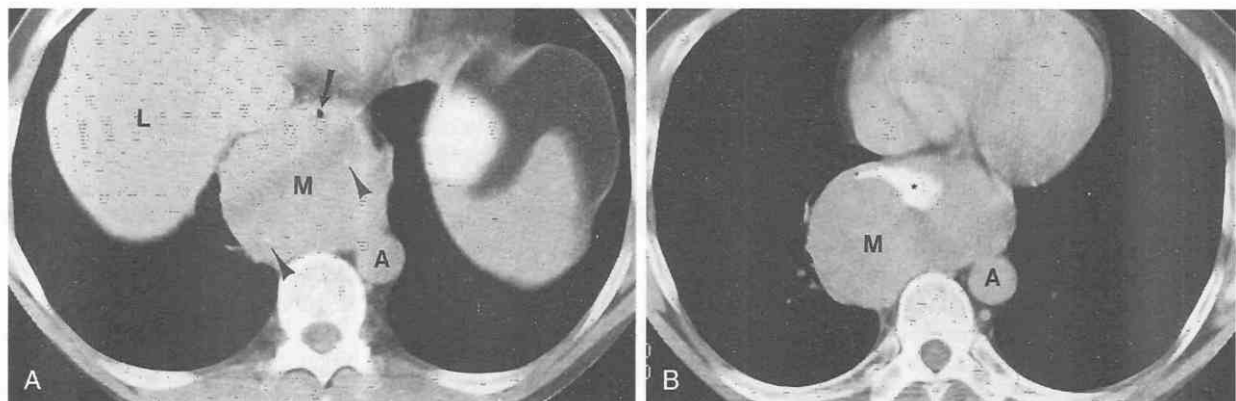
Esophageal leiomyoma. *A*, CT shows large middle-mediastinal mass with focal punctate calcifications (*arrowheads*). The esophagus is displaced anteriorly (*arrow*). The CT appearance is nonspecific and the origin of mass is uncertain. *A*, aorta; *L*, liver; *M*, mass. *B*, CT following ingestion of oral barium reveals distortion of esophageal lumen (*asterisk*), consistent with a mass arising within the wall of the esophagus. Resection confirmed leiomyoma. *A*, aorta; *M*, mass.
